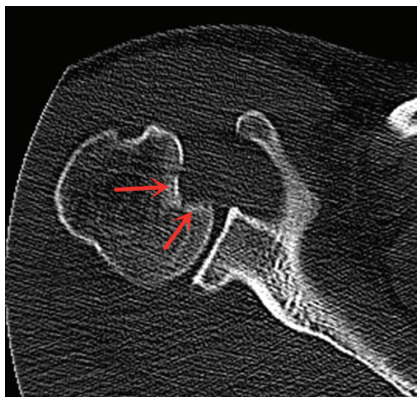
CT 显示反 Hill-Sachs 损伤,肱骨头严重压缩性骨折(红色箭头所示)
